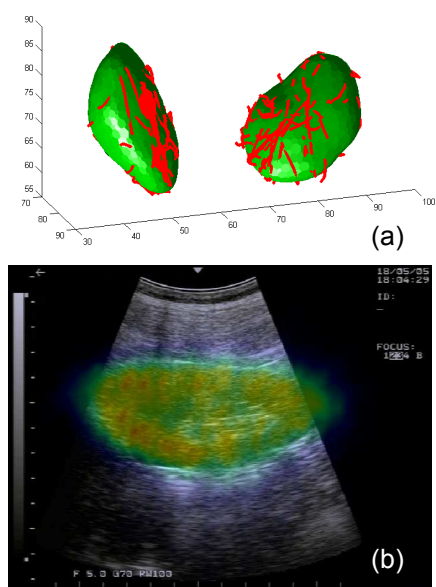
(a) 3D kidneys model and the points found in the 2.5D US image, after the registration. (b) Example of SPECT/US images registration.
